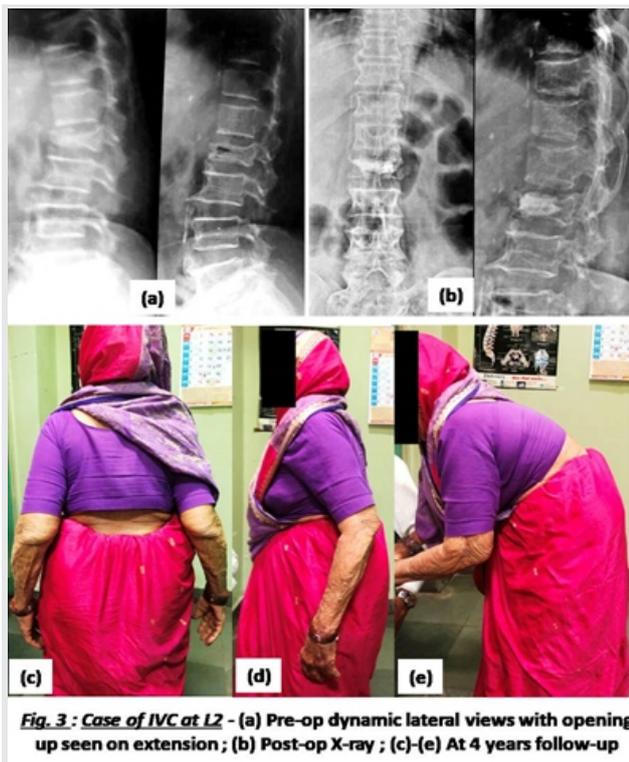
Case of IVC at L2 - (a) Pre-op dynamic lateral views with opening up seen on extension; (b) Post-op X-ray; (c)-(e) At 4 years follow-up
